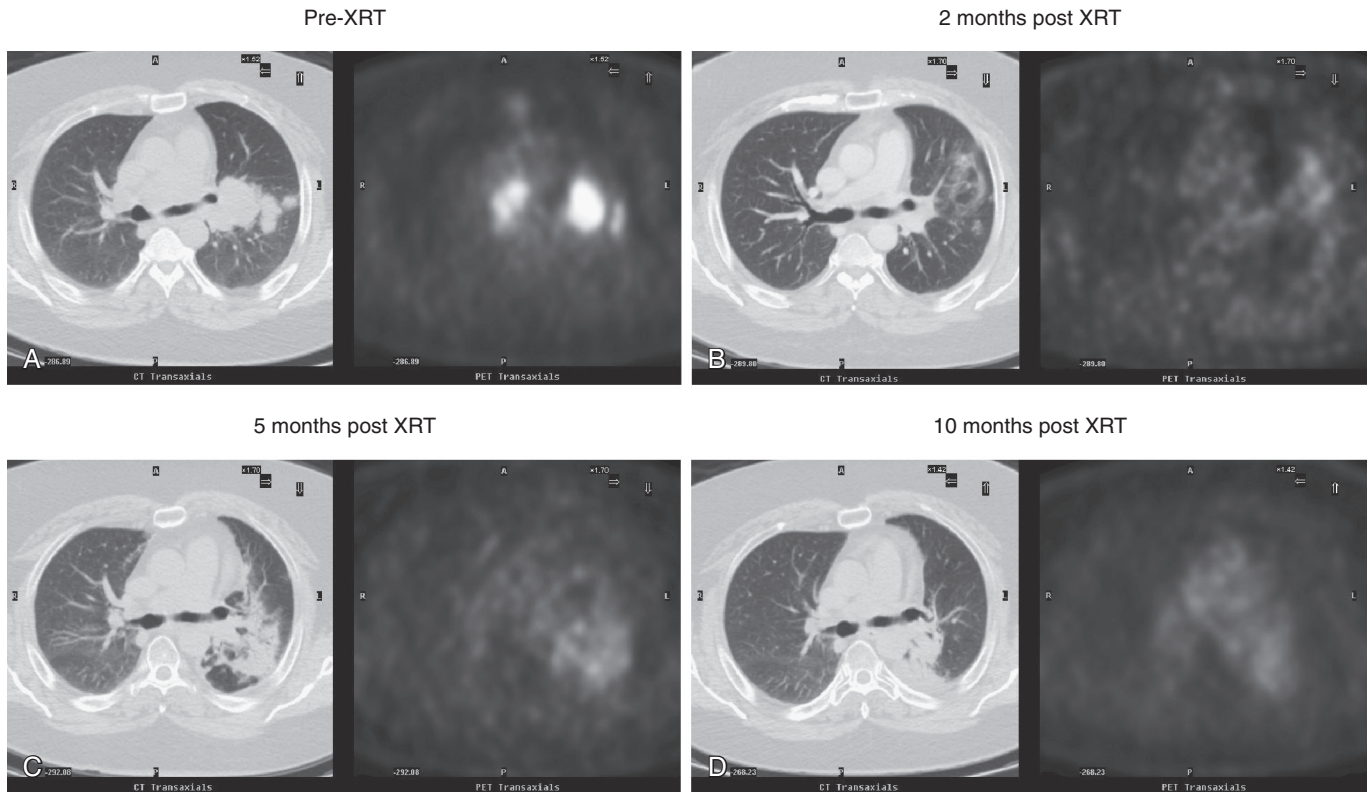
Evolution of posttreatment changes in the lung following radiation therapy. Pretherapy PET/CT scan (A) demonstrates bilateral hilar masses, predominantly on the left. PET/CT at 2, 5, and 10 months following radiation therapy (B-D) include evolving atelectasis and bronchiectasis on CT, with associated mild homogeneous FDG accumulation. The geographic distribution and absence of focal FDG accumulation are characteristic of expected postradiation changes.
